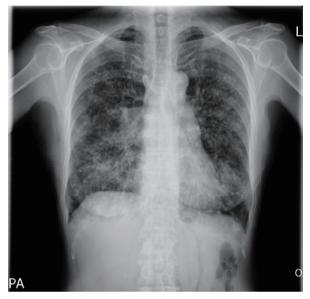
Chest radiography displays bilateral diffuse small nodular shadows and focal tram-like or linear opacities with mild hyperinflation.
